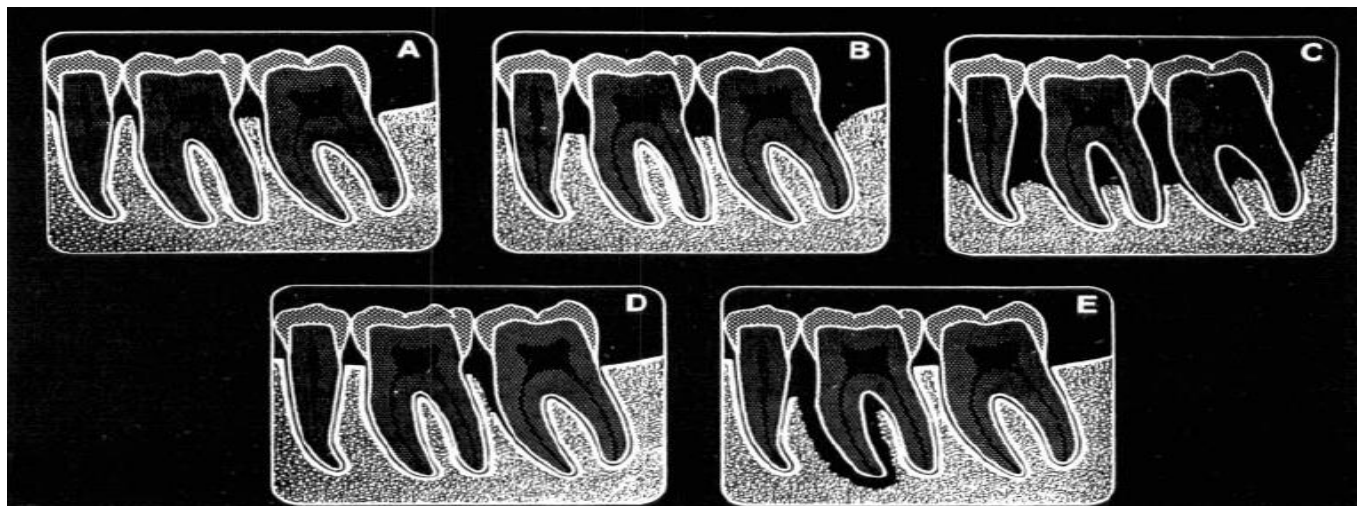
various radiographic appearance of apical inflammation
